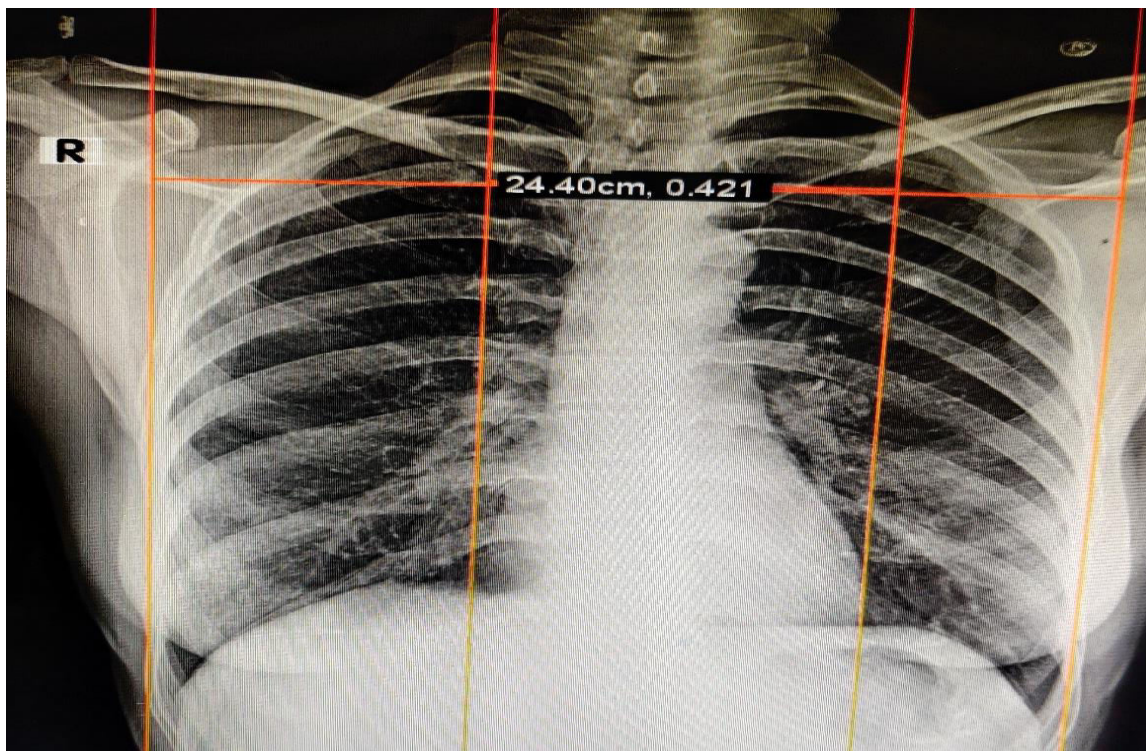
Radiographic measurements using software.
